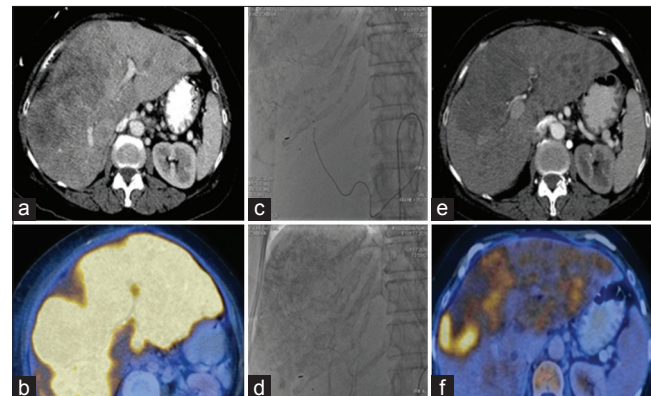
60yearold female patient with postoperative status for carcinoma rectosigmoid junction and hepatic metastases. Contrastenhanced computed tomography (a) Multiple hypervascular lesions in both lobes of liver with significant activity on positron emission tomography scan (b) Patient underwent transarterial radioembolization with Iodine¹³¹lipiodol (c and d). Followup scan demonstrates Lipiodol deposition after transarterial radioembolization with Iodine¹³¹Lipiodol within the hyper vascular lesions and reduction in size and enhancement of lesions (e) with significantly reduced positron emission tomography activity (f)
